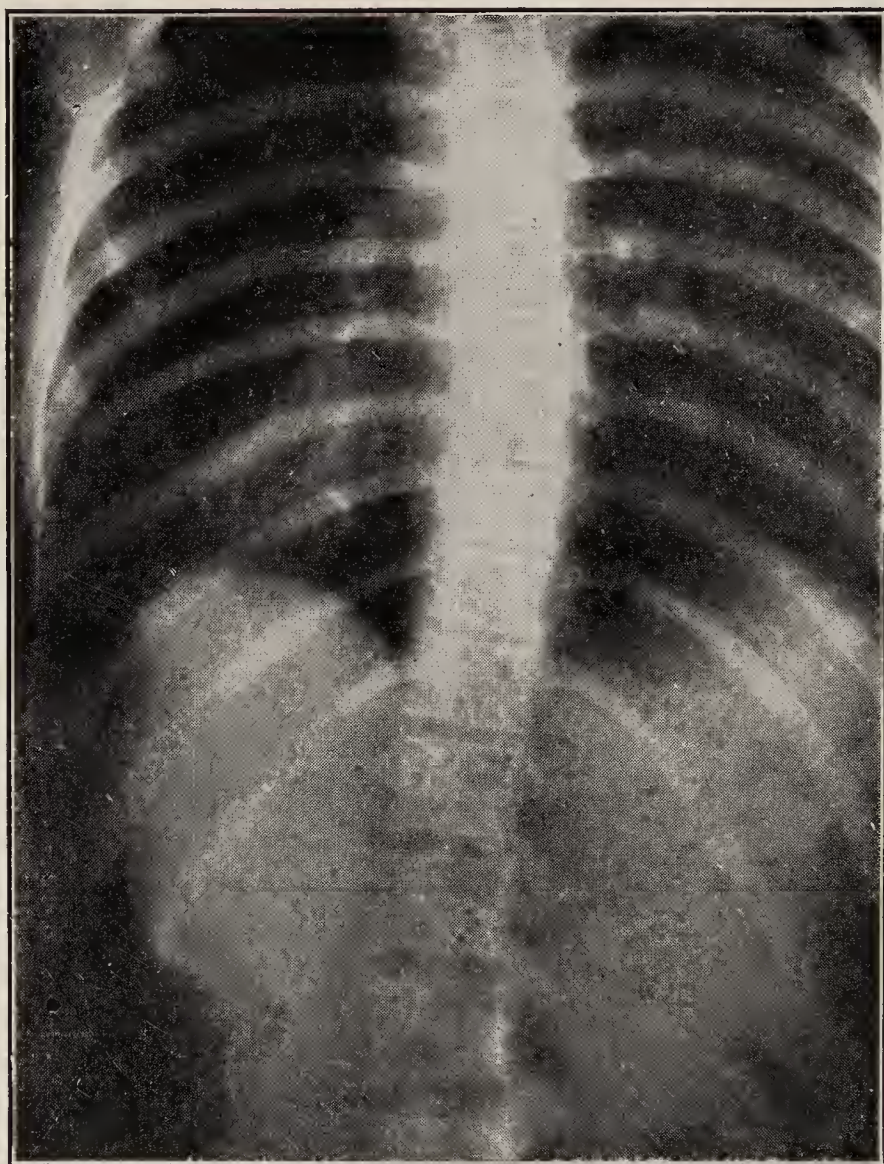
X-ray of slight right dorsal, left lumbar curve, showing dense shadow on concave side of curve.
